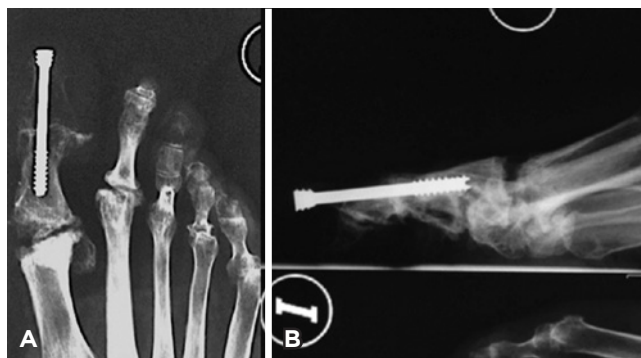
Postoperative radiograph. Metatarsophalangeal arthroplasty combined with interphalangeal arthrodesis.
